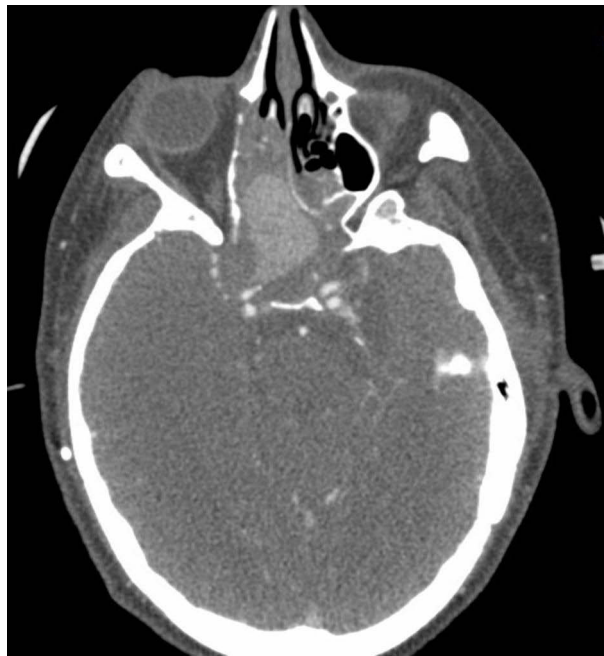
Axial view of the head CT with contrast showing a pseudoaneurysm of the cavernous portion of the right internal carotid artery protruding into the ethmoidal sinus.
